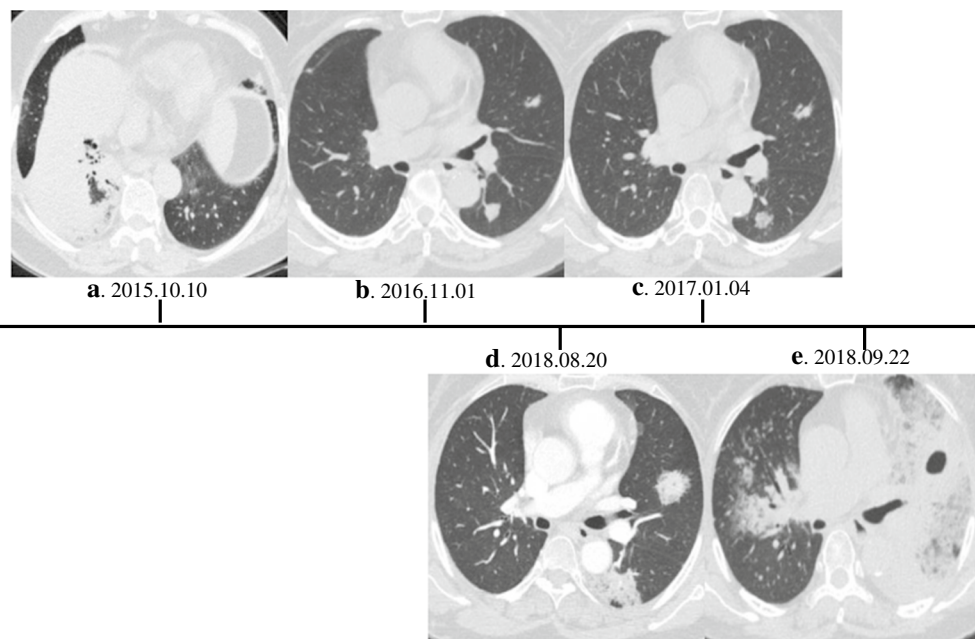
Serial CT images in pneumonic-type lung mucinous adenocarcinoma. a A 62-year-old woman came to our hospital for a CT examination because of repeated cough and sputum. The CT images showed consolidation with a diameter greater than 7 cm in the right lower lobe. This tumor was classified as clinical T4N0M0 after PET-CT examination. Anti-inflammatory treatment was ineffective. Therefore, surgical resection was performed on 10 October 2015. The lesion was pathologically confirmed as LMA without lymph node metastasis and lymphatic and vascular involvement and carried a KRAS mutation. In addition, this patient was treated with chemotherapy in the first, third, and fourth months after surgery. b In routine reexamination, few new lesions in the bilateral lung were detected. A metastatic nodule was suspected and treated with chemotherapy.
